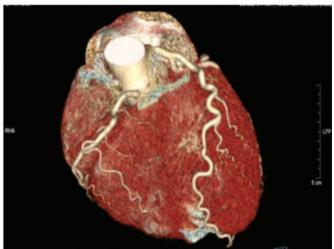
Cardiac CT – volume rendered images
